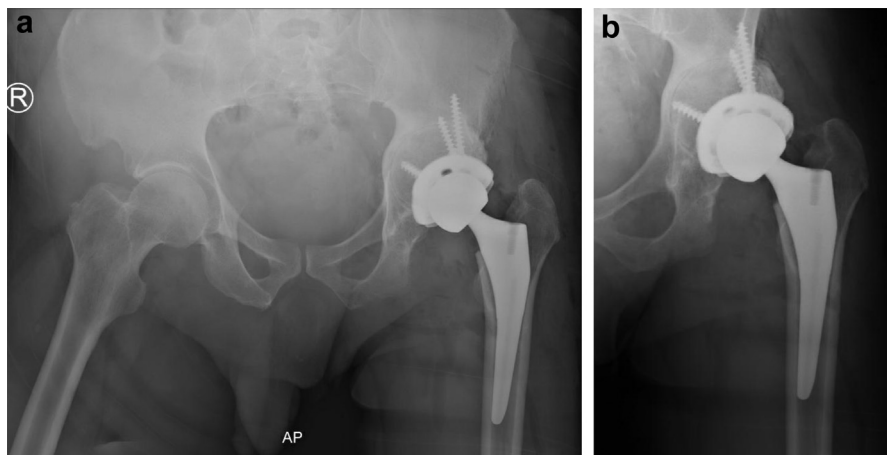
Immediate postoperative AP pelvis (a) and AP hip (b) radiographs. AP, anteroposterior.
